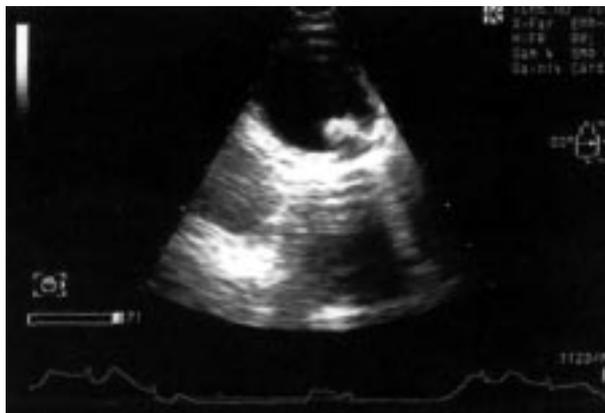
Large mobile atheroma within the descending aorta lumen (transesophageal echocardiography).
